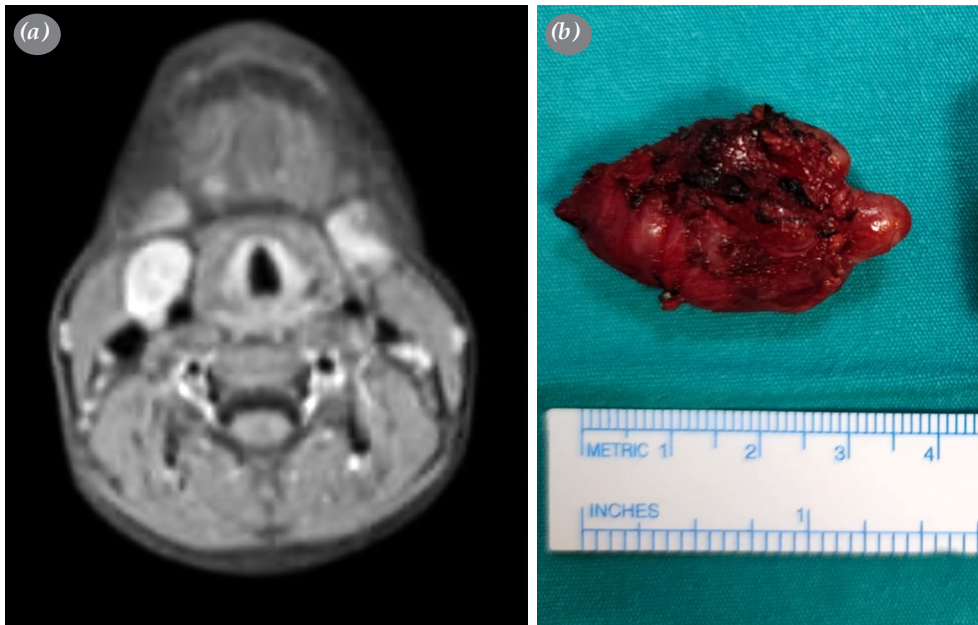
(a) A vascularized mass with a diameter of 4×4 cm is seen on magnetic resonance imaging angiography surrounding the right common, internal, and external carotid arteries. (b) Intraoperative image of the resected carotid body tumor.
